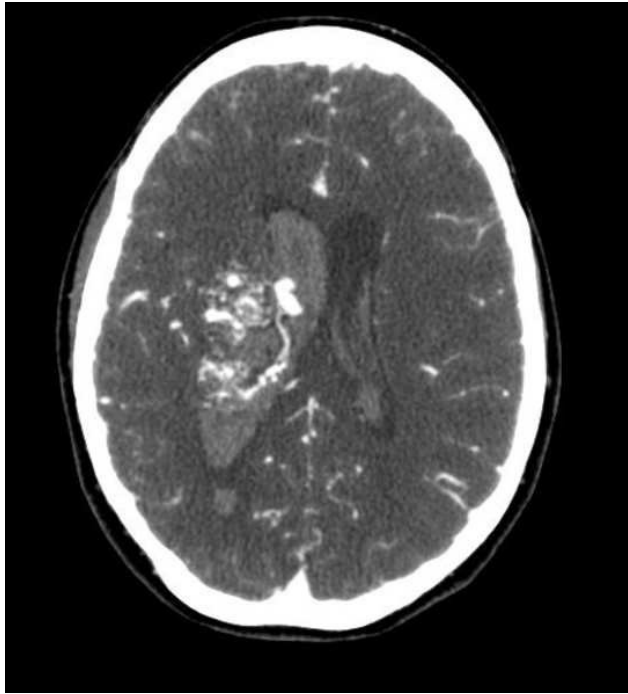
CT angiography of the head, axial cut, of 27 year old G1P0 woman. Note presence of AVM in right lentiform nucleus and right thalamus.
